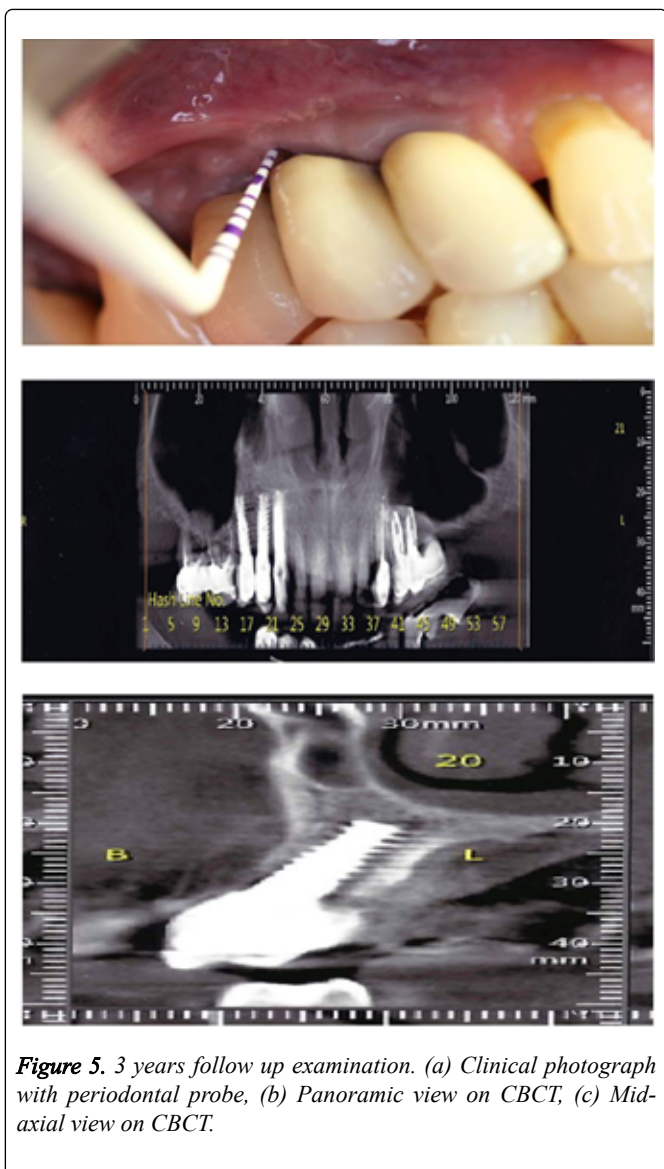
3 years follow up examination. (a) Clinical photograph with periodontal probe, (b) Panoramic view on CBCT, (c) Mid-axial view on CBCT.
